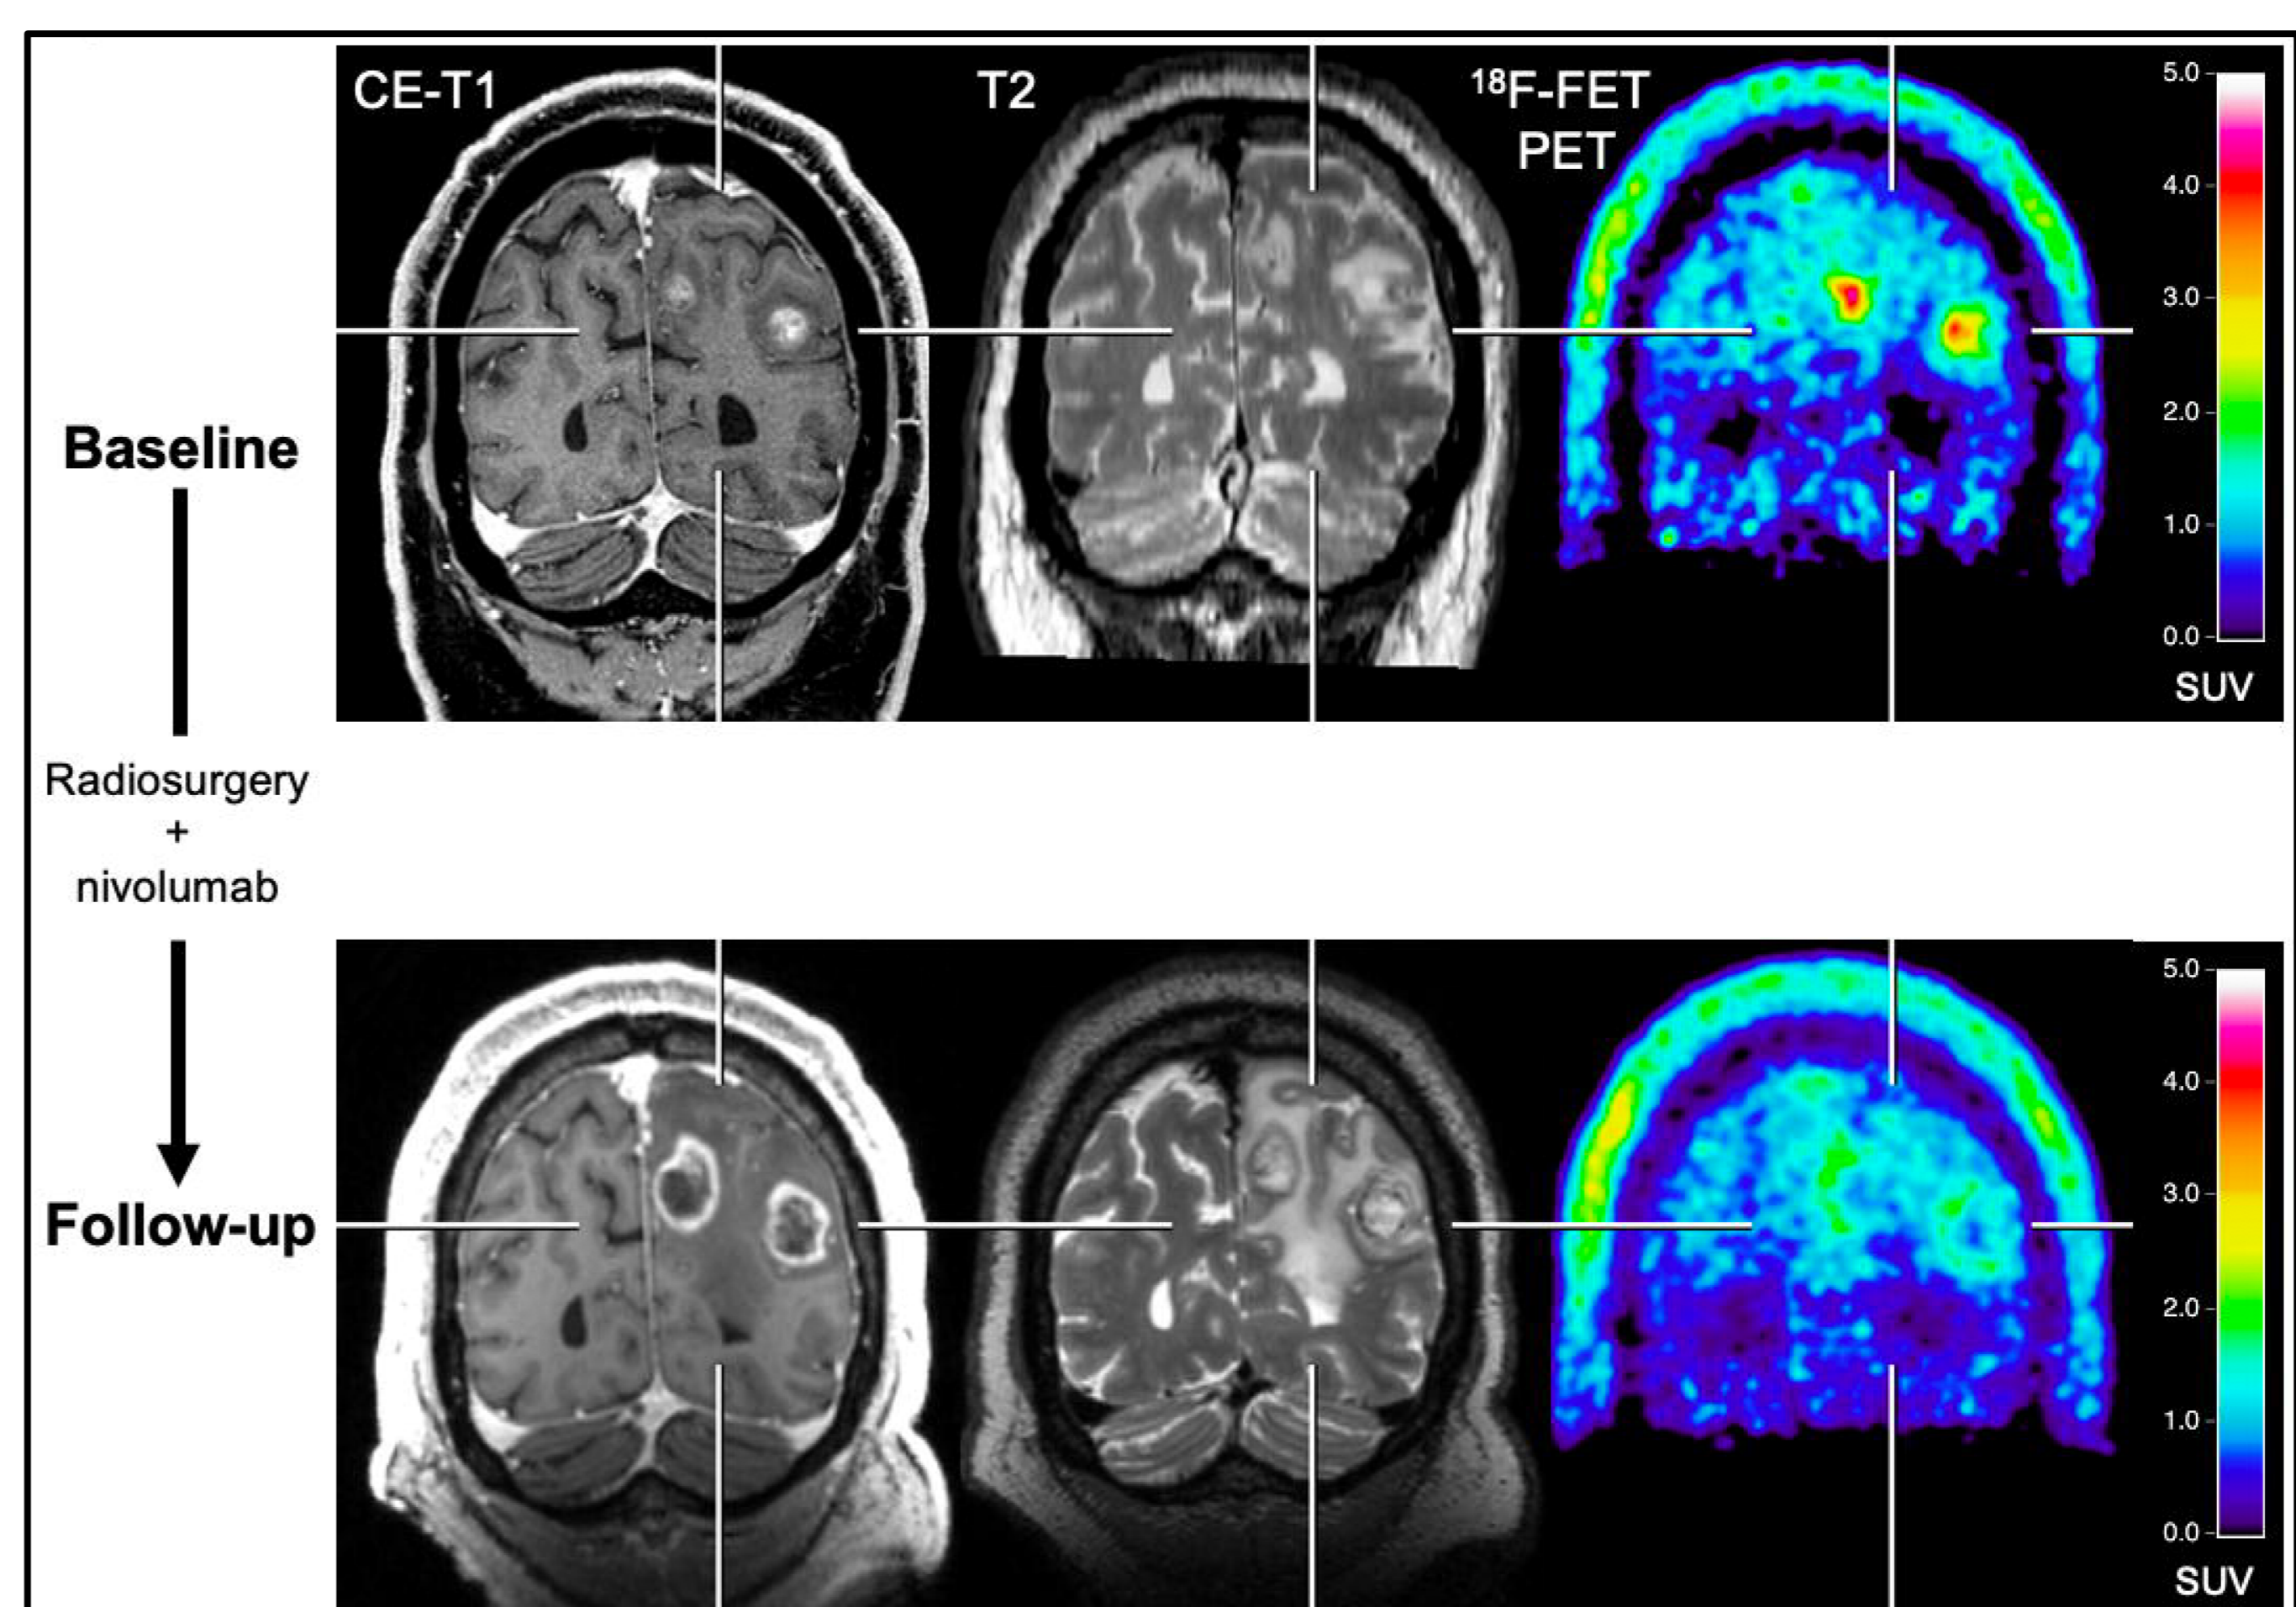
Following radiosurgery concurrent to nivolumab in patient with melanoma brain metastases, FET PET at follow-up 12 weeks after treatment initiation (bottom row) shows a significant decrease of metabolic activity (TBRmean, -28%) compared to baseline (top row). In contrast, MRI changes were consistent with progression according to RANO criteria for brain metastases. The reduction of metabolic activity was associated with a stable clinical course over 10 months
